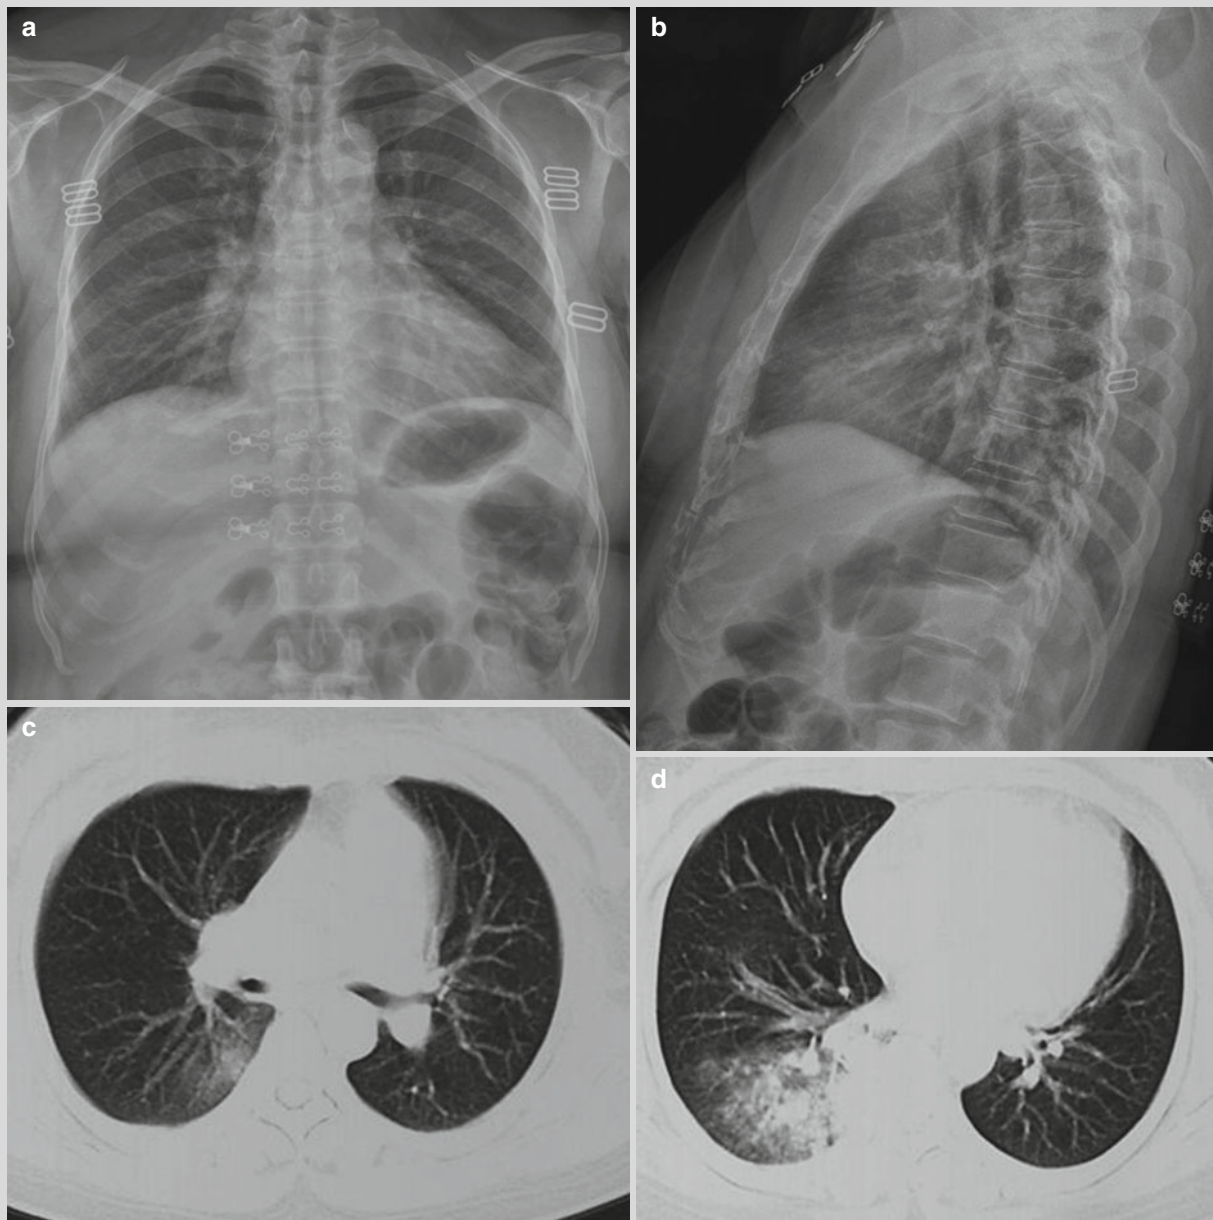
On d 2 after onset, anterior-posterior and lateral X-ray showed poorly defined small flake of high density opacity near the cardiophrenic angle in the right lower lung field. And lateral X-ray demonstrated poorly defined small flake of opacity in the overlapping area of posterior costophrenic angle and thoracic vertebrae in the right lower lung field (a, b). On d 3 after onset, chest CT scan showed flake of ground glass opacity in the posterior basilar segment of right lower lung lobe (c). The right lower lung lobe was revealed with large flake of opacity with mixed GGO density and parenchymal density (d). On d 6 after onset, chest CT scan demonstrated large consolidation in the posterior basilar segment of right lower lung (e). The right middle
